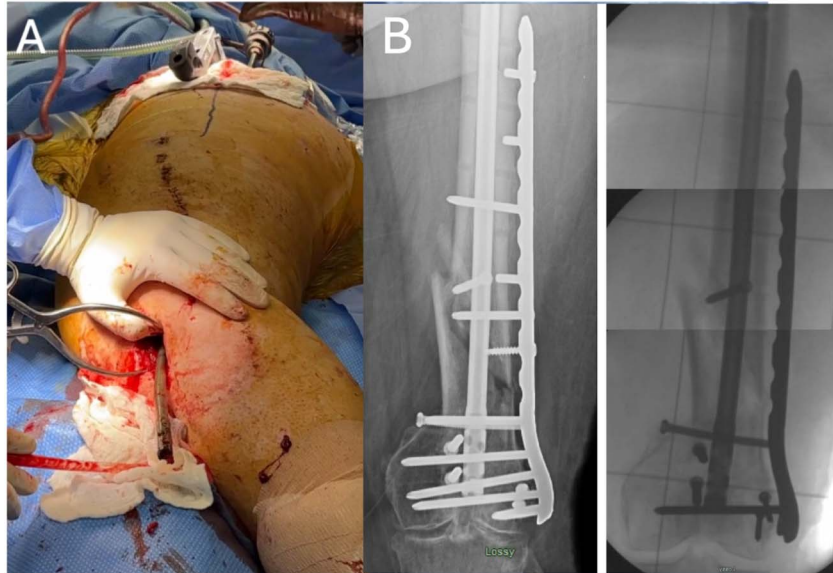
A, Case in Figure 3 with the stripped end cap requiring alternate kissing nail extraction technique in the lateral position. B, Preoperative X-ray of the femur with IN displaying interlocking screws that correlate with extra incisions in (A).
